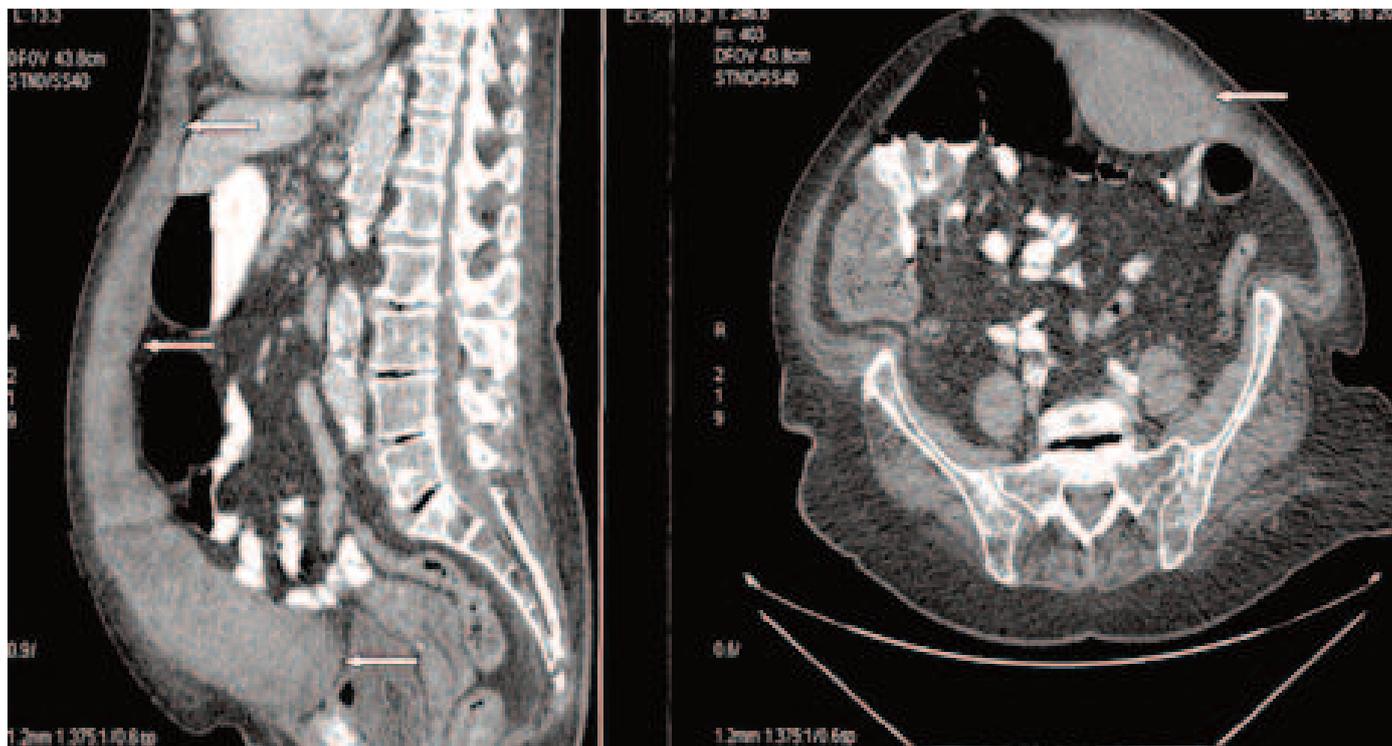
Computed tomography showing long acute hematoma in the left rectus abdominis (Arrows)
